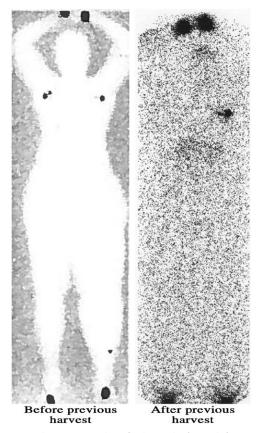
Lymphoscintigraphic findings before (*left*) and after (*right*) supraclavicular lymph node harvest. Note loss of tracer uptake in the right axilla in the postoperative image.
